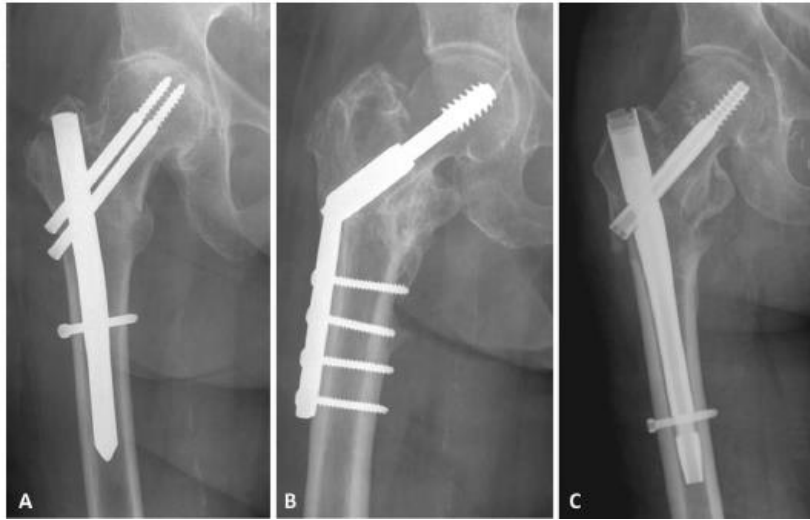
Anteroposterior radiographs showing treatment of fractures with (from left) H2, DHS, Gamma3
